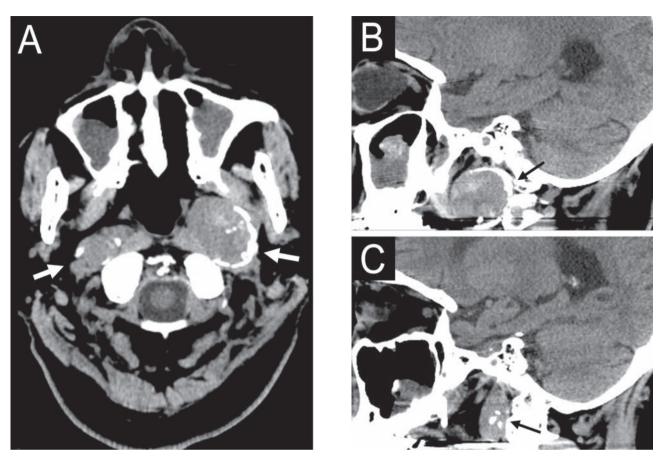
(A) Axial CT shows well-defined heterogenous soft tissue mass lesions in the bilateral parapharyngeal spaces with irregular peripheral calcification (arrows). The two mass lesions measured $37 \text{ mm} \times 36 \text{ mm} \times 26 \text{ mm}$ on the left with ovoid shape on sagittal view (B, small arrow), and 26 mm x 20 mm x 16 mm on the right with elliptic shape on sagittal view (C, small arrow), respectively.
